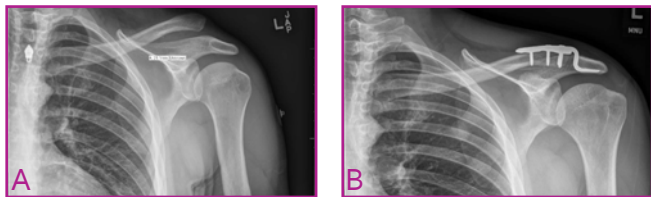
Radiographs of a 16-year-old soccer player, who fell onto his left shoulder, which show anteroposterior views. (A) Preoperatively, showing signs of a type V separation of the acromioclavicular joint, with the distance of the coracoclavicular ligament displaced at greater than 100%. (B) Postoperatively, showing successful fixation with use of hook plate.
